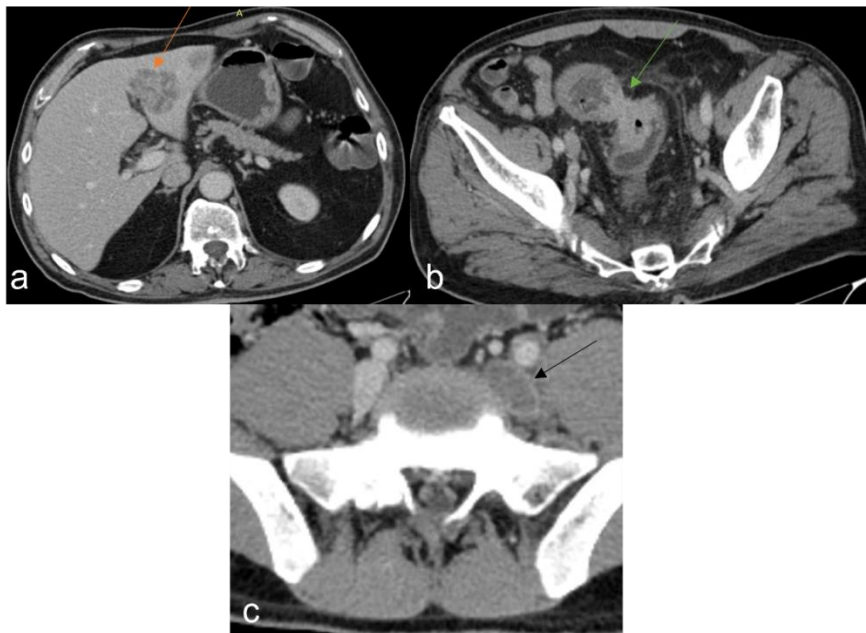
Abdominal and pelvic CT, portal venous phase: a. liver metastases (orange arrow); b. sigmoid colon cancer (green arrow); c. left common iliac vein thrombosis (black arrow)
